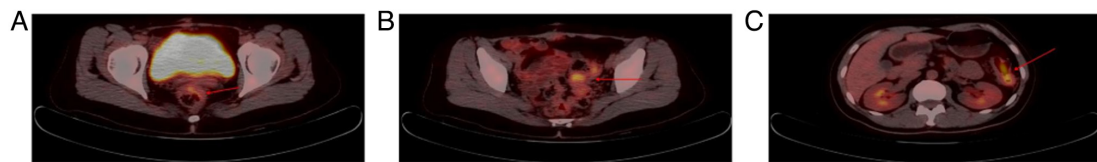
18F-FDG positron emission computerized tomography. (A) Local bowel wall thickening of the upper rectum with increased glucose metabolism; (B) local bowel wall thickening of the sigmoid colon with increased glucose metabolism; and (C) local bowel wall thickening of the splenic flexure of the colon with increased glucose metabolism.
